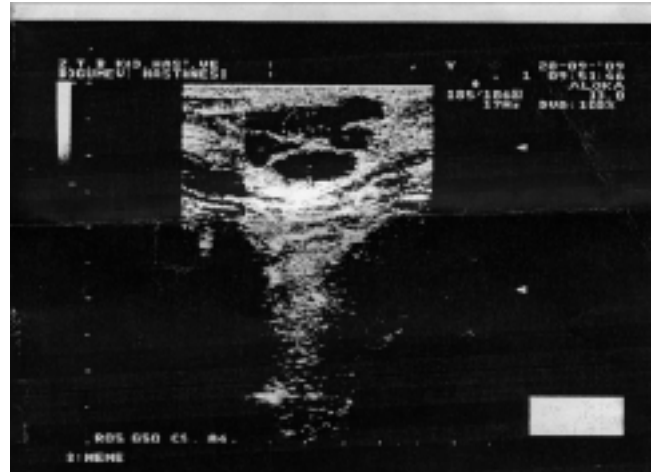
Sonographic appearance of scar endometriosis
